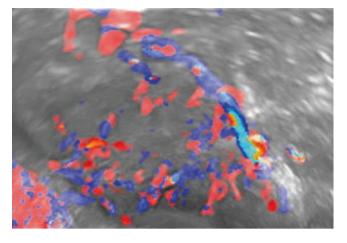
3D HD Doppler with glass body display, showing abnormal morphology of tumour vessels in a case of carcinoma cervix
